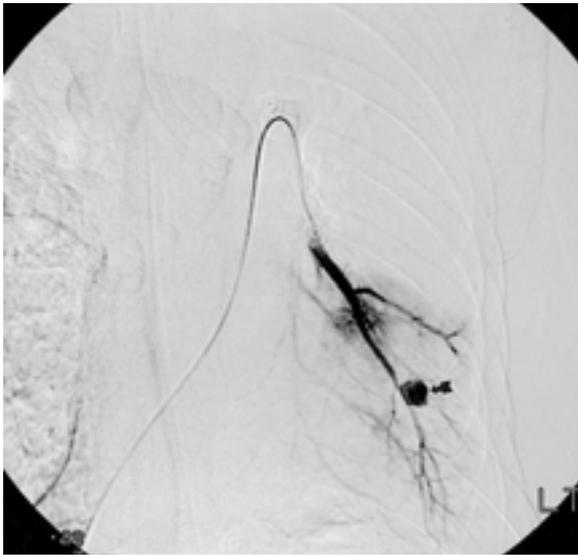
A. Left bronchial angiogram shows hypervascularity(arrows), enlargement and tortuosity(arrowheads) of bronchial artery. B. Postembolization image of left bronchial artery demonstrates complete occlusion of bronchial artery. C. Chest radiograph shows destructive changes in the both upper lobes and thin wall cavity (arrows) in the left lower lobe. Double lumen intubation set in the trachea (arrowheads). D. Chest radiograph shows air meniscus sign in the thin wall cavity in the left lower lobe.
